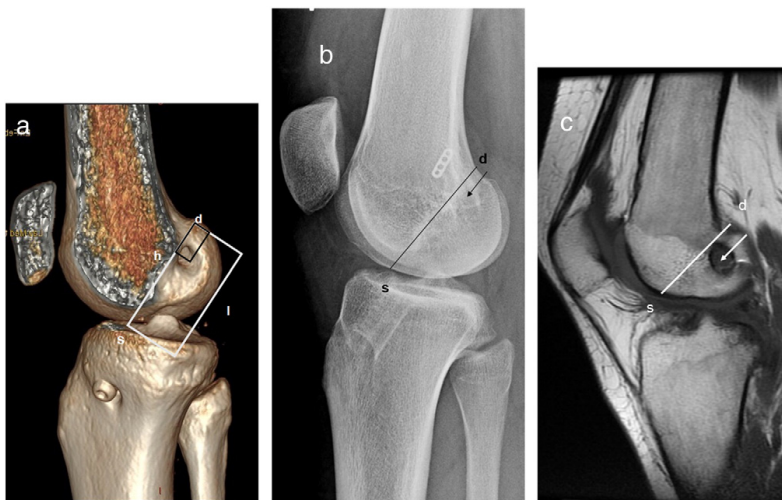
The method for measurement of the femoral tunnel placement. a) 3DCT image, tunnel placement in the deep–shallow and high–low directions indicated with a box/grid. b) Deep–shallow measurements on a lateral radiograph. c) Deep–shallow measurements on a sagittal MRI. d = deep, s = shallow, h = high, l = low.
